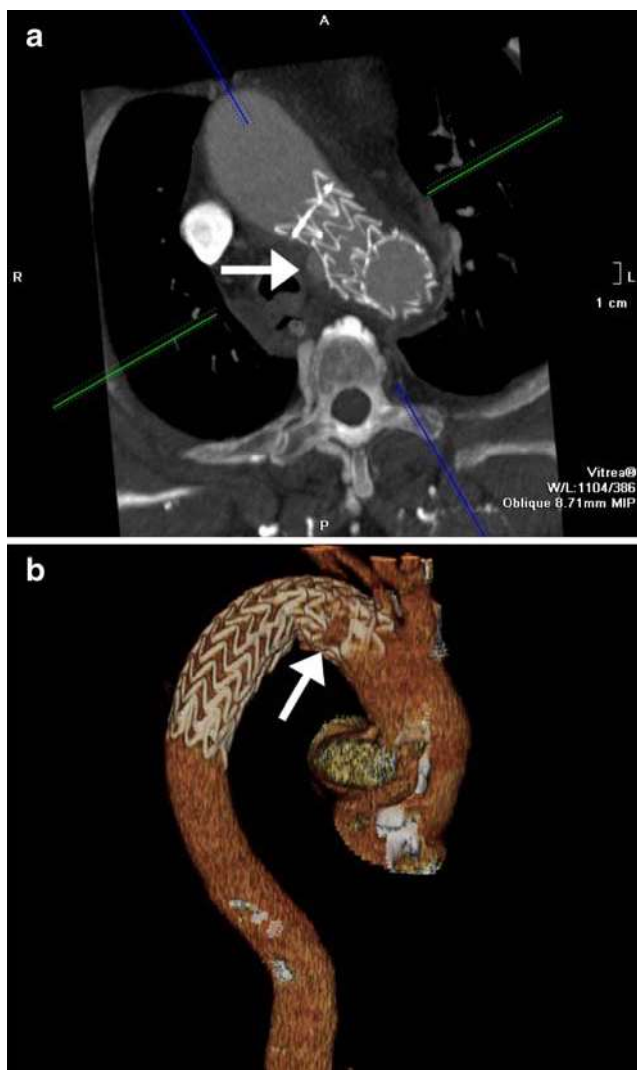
Early postoperative CTA after endograft implantation. a Double oblique paracoronary maximum-intensity projection through the aortic arch indicating a small endoleak type I and II (arrow). b Volume rendering demonstrating correct deployment of the endograft distal to the patent left carotid and showing a retrograde perfusion of the left subclavian artery as well as a small endoleak (arrow)
